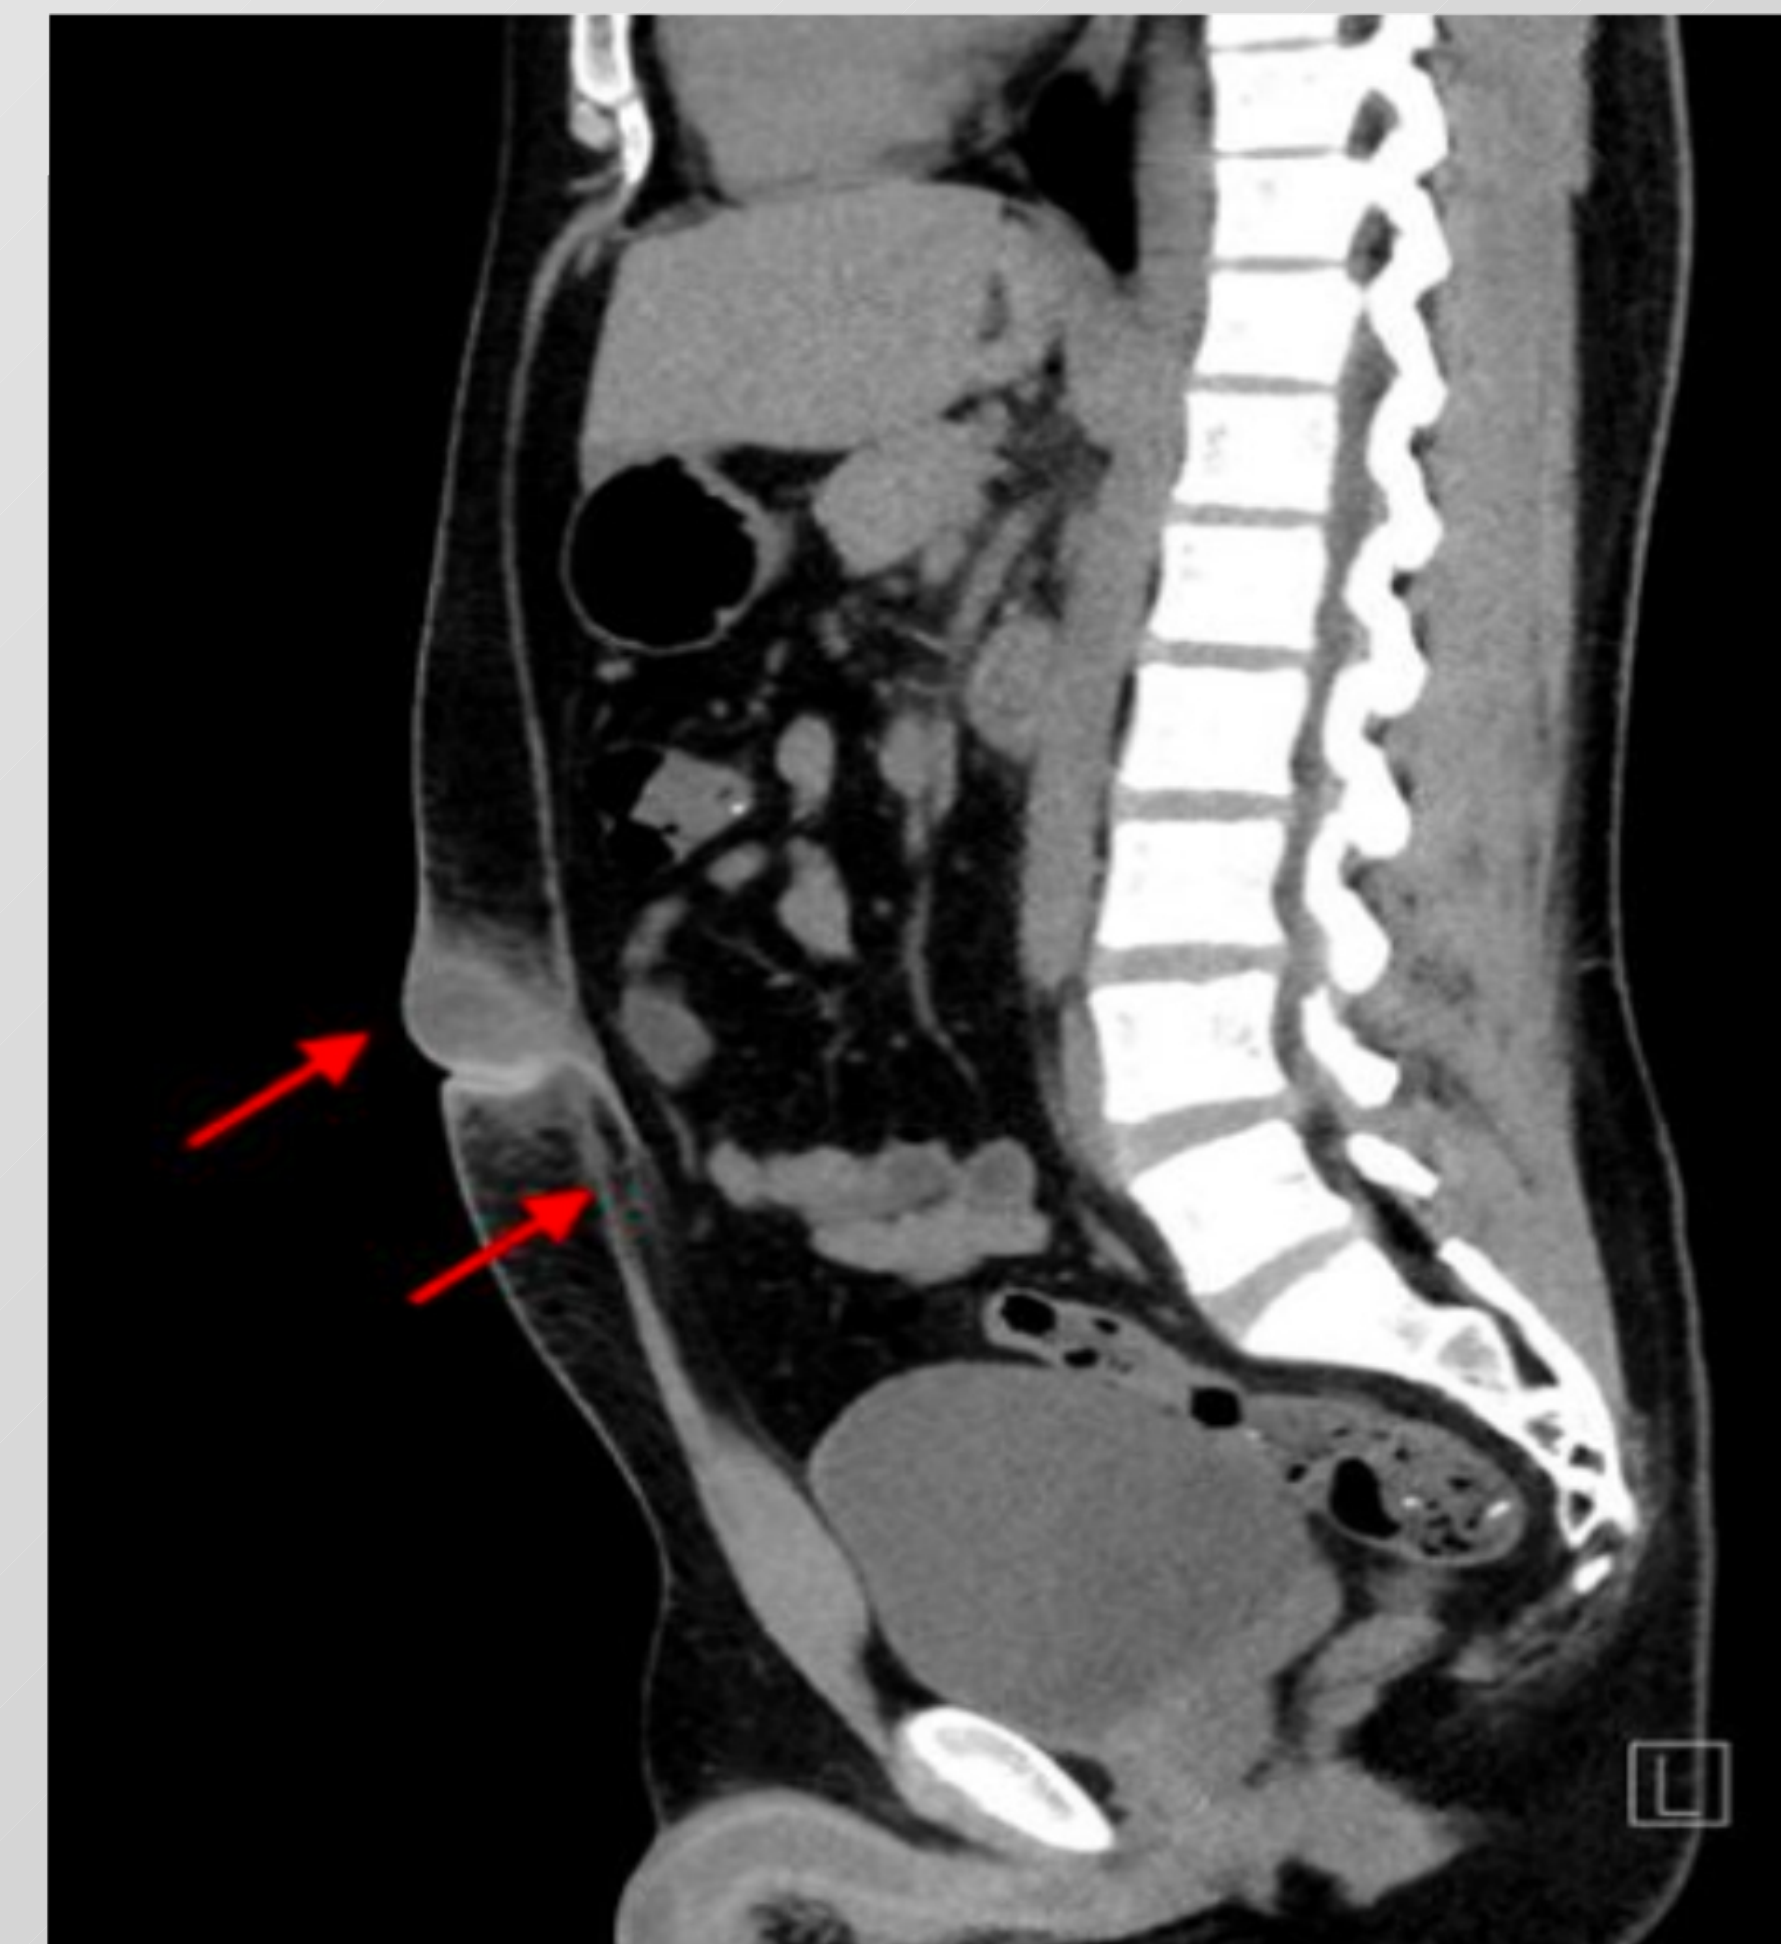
Sagittal CT Image of patient # 2 with infected urachal cyst with red arrows.
